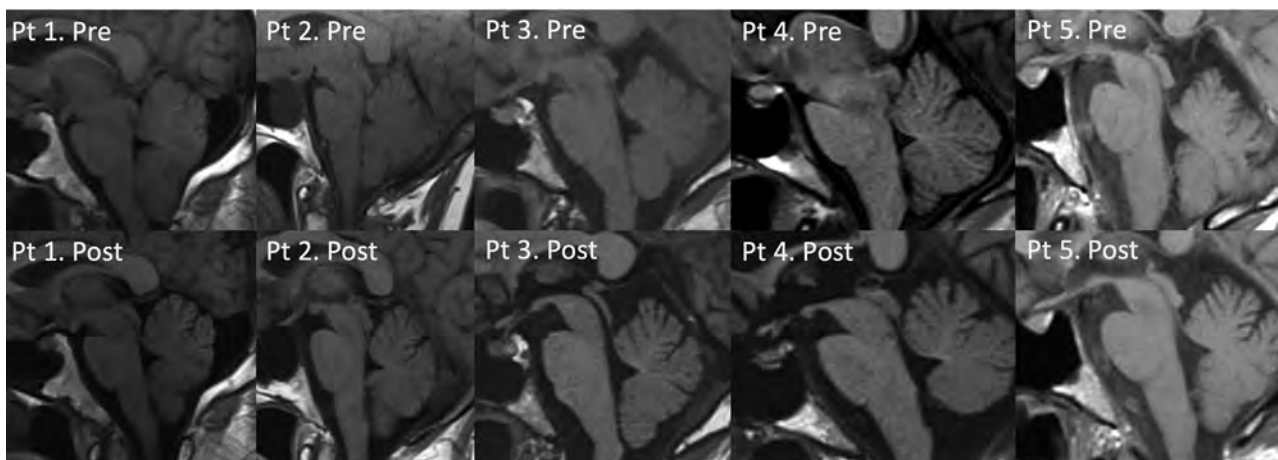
Pre- and posttreatment sagittal T1-weighted MRIs in patients 1–5. Patient 1 had a decreased mamillopontine distance, effacement of the prepontine and suprasellar cistern, tonsillar descent, and engorgement of the pituitary gland. Following embolization, there was normalization of the suprasellar cistern and mamillopontine cistern distances as well as the prepontine cistern and resolution of tonsillar ectopia. Pituitary engorgement improved as well. Patient 2 had prepontine and suprasellar cistern effacement and decreased mamillopontine distance and tonsillar ectopia. Following embolization, these all resolved. Note the incidental pituitary cyst. Patient 3 had decreased mamillopontine distance and effacement of the suprasellar cistern and prepontine cistern, all of which normalized postembolization. Patient 4 had effacement of the suprasellar cistern and prepontine cistern and decreased mamillopontine distance, all of which resolved on follow-up MR imaging. Patient 5 had effacement of the suprasellar cistern and prepontine cistern. There was still suprasellar cistern effacement on posttreatment MR imaging, but the prepontine cistern distance normalized. Pt indicates patient; Pre, pretreatment; Post, posttreatment.
